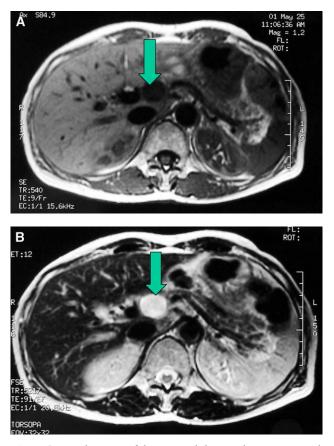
Spin-echo MRI of the upper abdomen showing a round lesion in the head of the pancreas that appears hypointense on T1-weighted image (A), with very high signal intensity on T2-weighted image (B). There is no sign of infiltration of the surrounding tissues.
